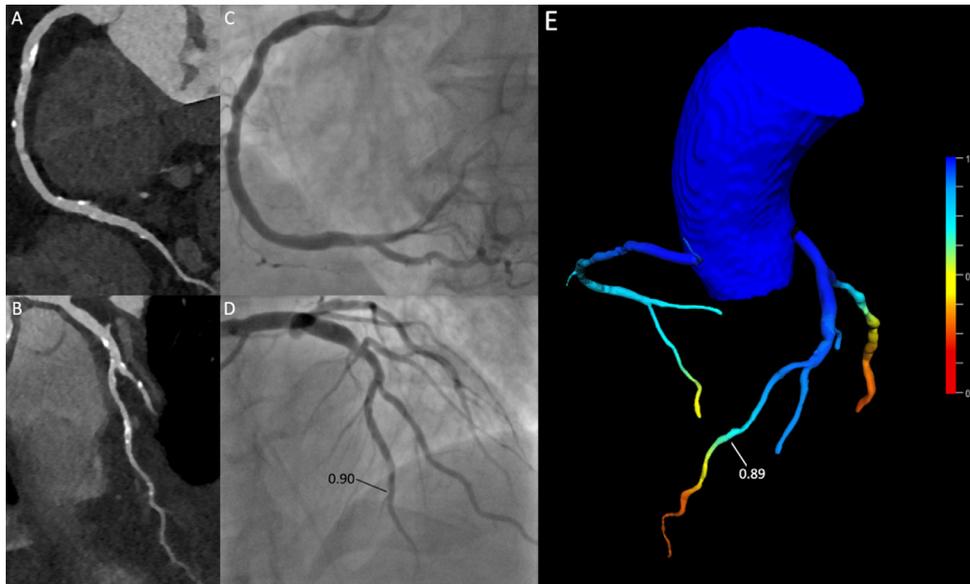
Coronary CT angiography, invasive coronary angiography, and CT-FFR in a single patient. The coronary CT angiography showed several moderate stenoses in the right (A) and left coronary artery (B), but the evaluation was hampered by the amount of calcium in the coronary arteries. Invasive coronary angiography showed no significant stenoses in right coronary artery (C) and multiple lesions in the left anterior descending artery with a FFR of 0.90 (D). The CT-FFR analysis showed comparable results with the invasively measured FFR (E).
